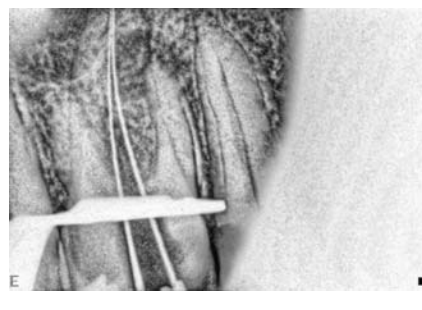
Periapical radiograph showing files in 2 palatal canals.
